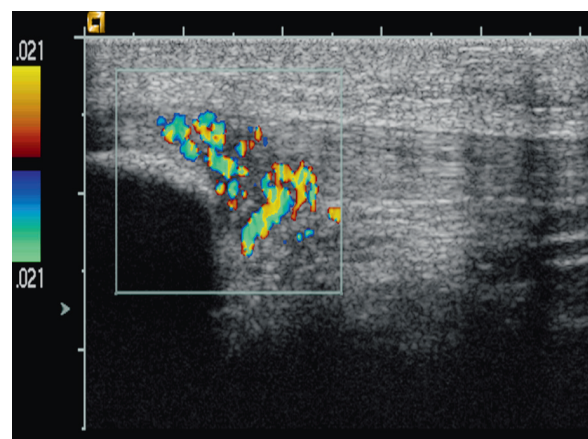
Gray-scale ultrasound and color Doppler examination of a patient with patellar tendinopathy/Jumper's knee, showing thickening of the proximal tendon, irregular tendon structure and hypoechoicity, and high blood flow (color) inside the tendon and outside the dorsal part of the tendon
